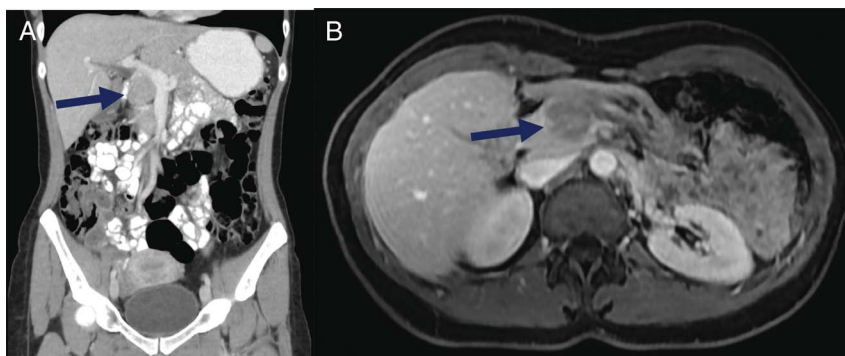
Computed tomography (A)/magnetic resonance (B) showing a hypodense/hypointense hypovascular nodule in the pancreatic head.
